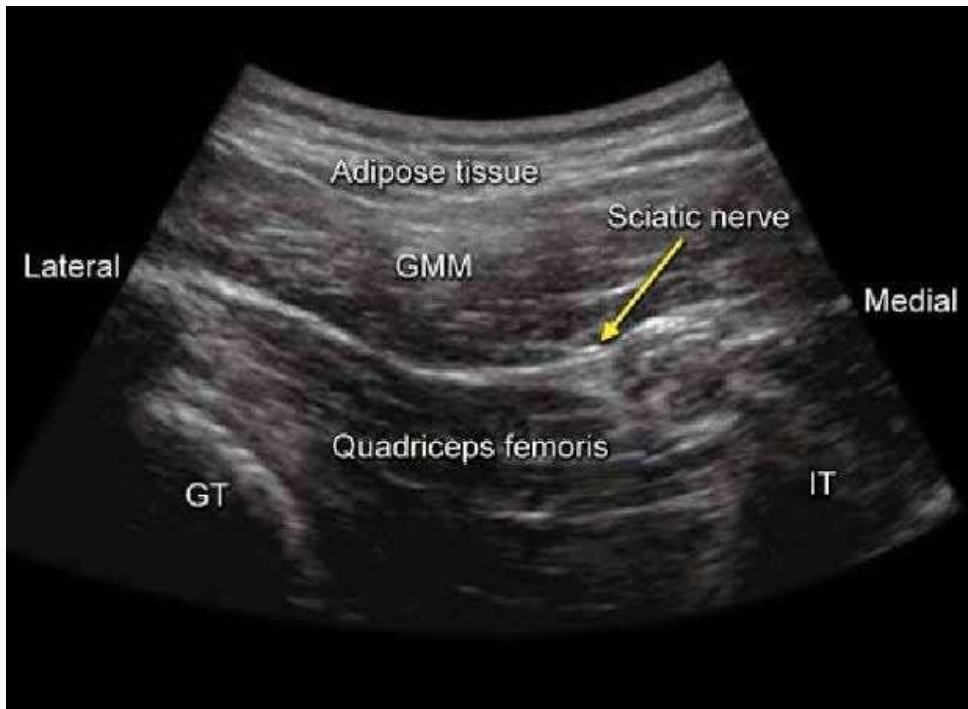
Sciatic nerve through posterior approach via ultrasound guided
